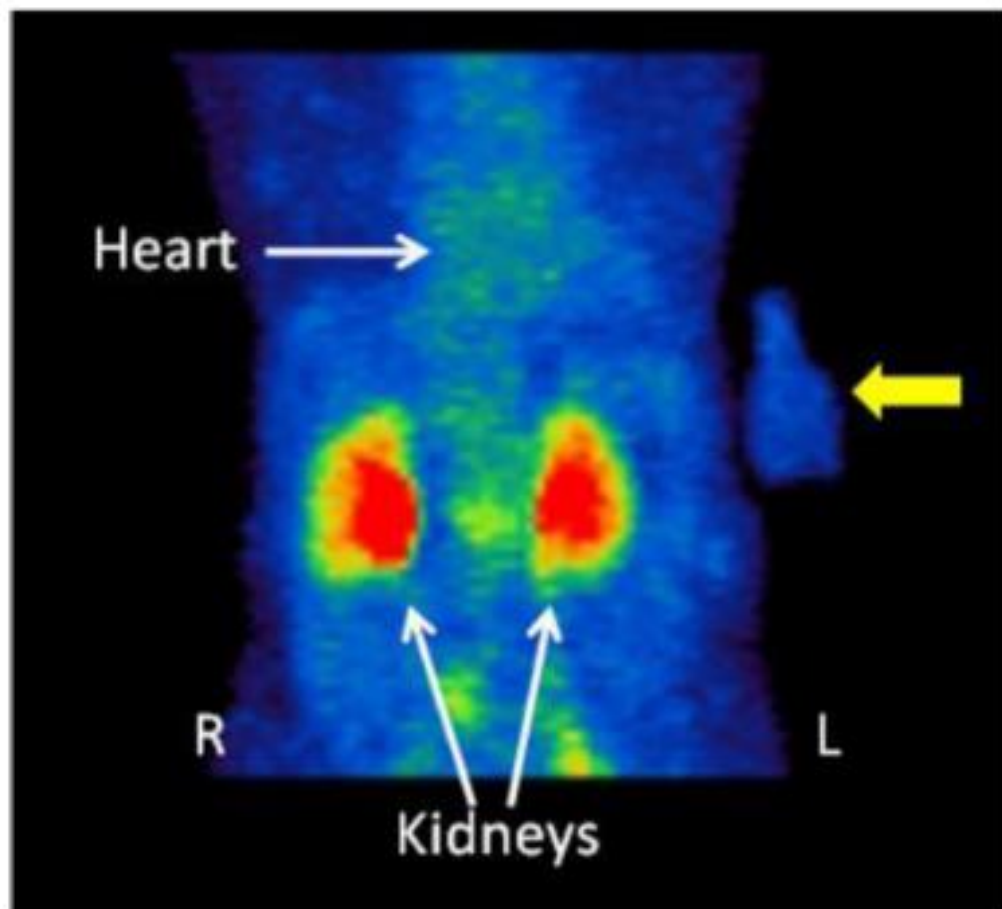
A maximum intensity projection image from the initial SPECT study for a subject (30 minutes after ^{177}Lu]Lu-DOTA-TATE administration), showing the location of the calibration flask (yellow arrow) relative to the subject, used by Bailey et al (taken from Bailey et al 2015) [111]
